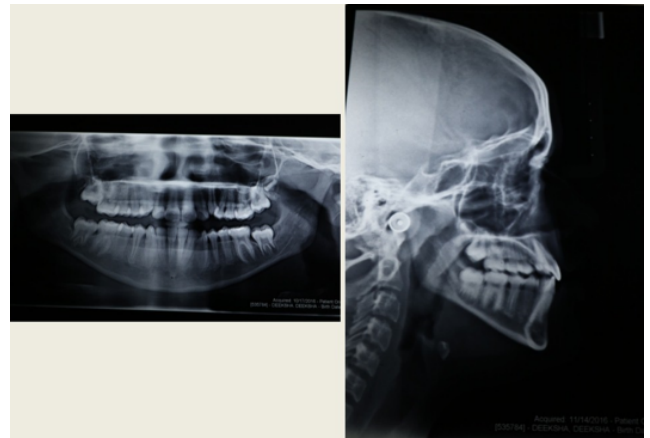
Post- treatment Radiograph
